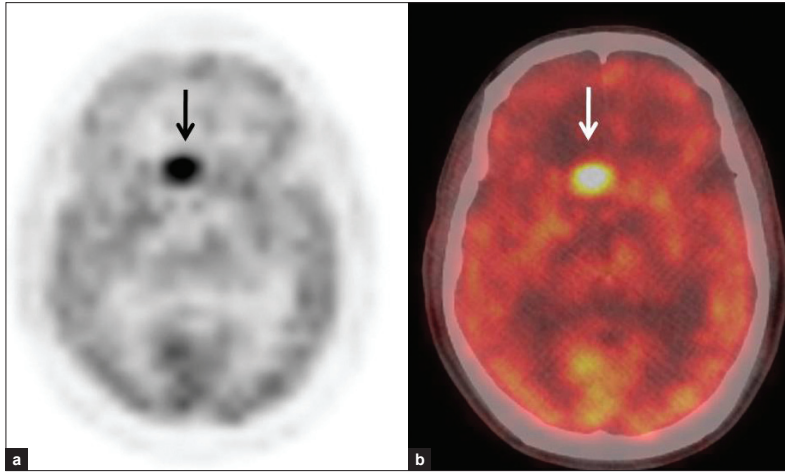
Treated case of melanoma of the toe. Focus of intense FDG uptake is seen in the midline anterior to the third ventricle on axial PET (a) and fused PET/CT images (b) suggesting the diagnosis of cerebral metastasis
